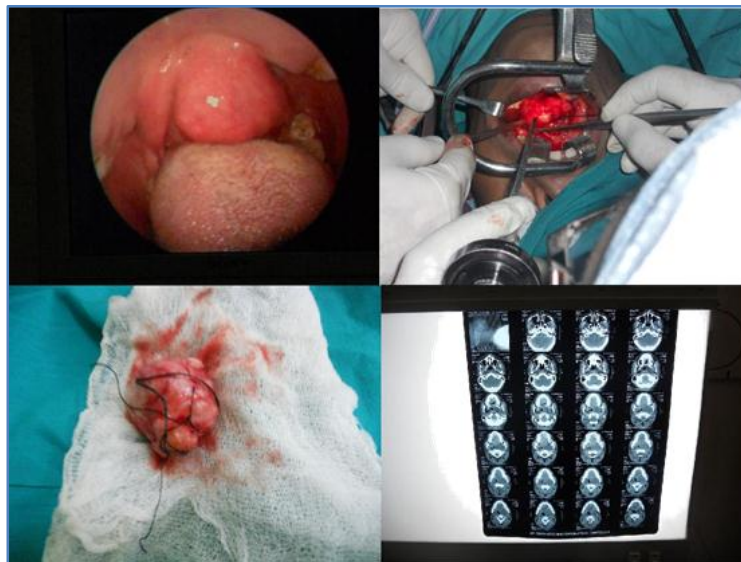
Showing the parapharyngeal tumor: Pre-operative picture; during surgery and CT Scan picture
